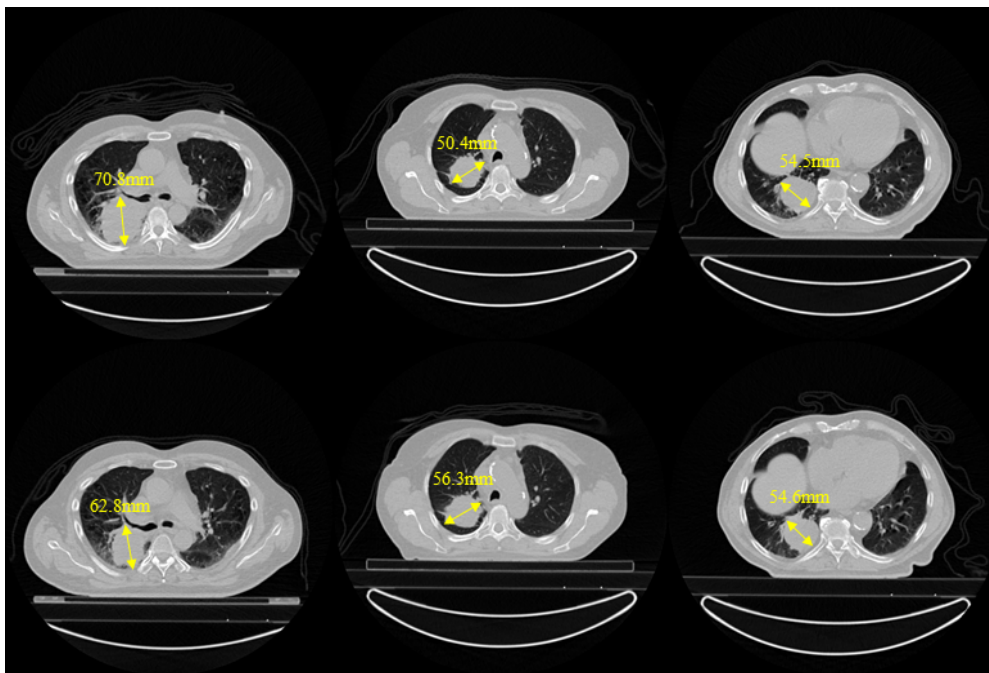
Measuring the changes in the size of lung tumors in computed tomography images. The axial slices in which the tumors appeared with the largest size were chosen, from which the diameter of the tumor in the most representative direction was measured. This manual procedure was examined for the pretreatment scan (first row) and the scans acquired from the second week of radiation therapy (second row).
